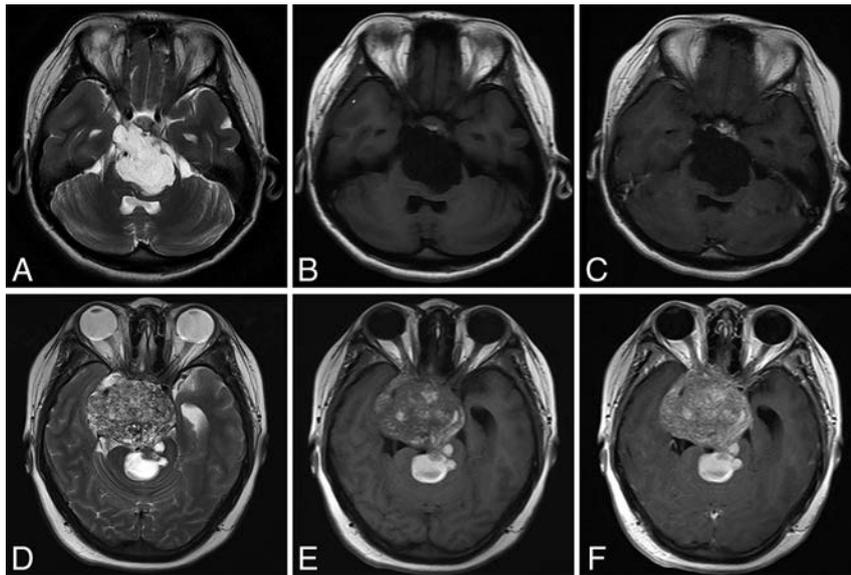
MR imaging of 2 patients with SBC. Patient 1 (A–C), 21-years of age. Pathologic findings were conventional chordoma. The patient underwent subtotal tumor resection with no progression at 48 months. A, Axial T2-weighted MR imaging. Tumor demonstrates homogeneous high signal intensity. B, Axial T1 FLAIR-weighted MR imaging. Tumor has relatively homogeneous hypointense signal compared with the pons. C, Enhanced T1 FLAIR MR imaging shows no enhancement of the lesion. Patient 2 (D–F), 25 years of age. Pathologic findings revealed conventional chordoma with necrosis and nuclear division. This patient underwent subtotal tumor resection with tumor progression at 8 months. D, Axial T2-weighted MR imaging demonstrates tumor heterogeneity. The signal intensity is relatively lower than that in patient 1. E, Axial T1 FLAIR MR imaging. The tumor is heterogeneous and hyperintense compared with the pons. F, Enhanced T1 FLAIR MR imaging. Tumor exhibits moderate enhancement.
